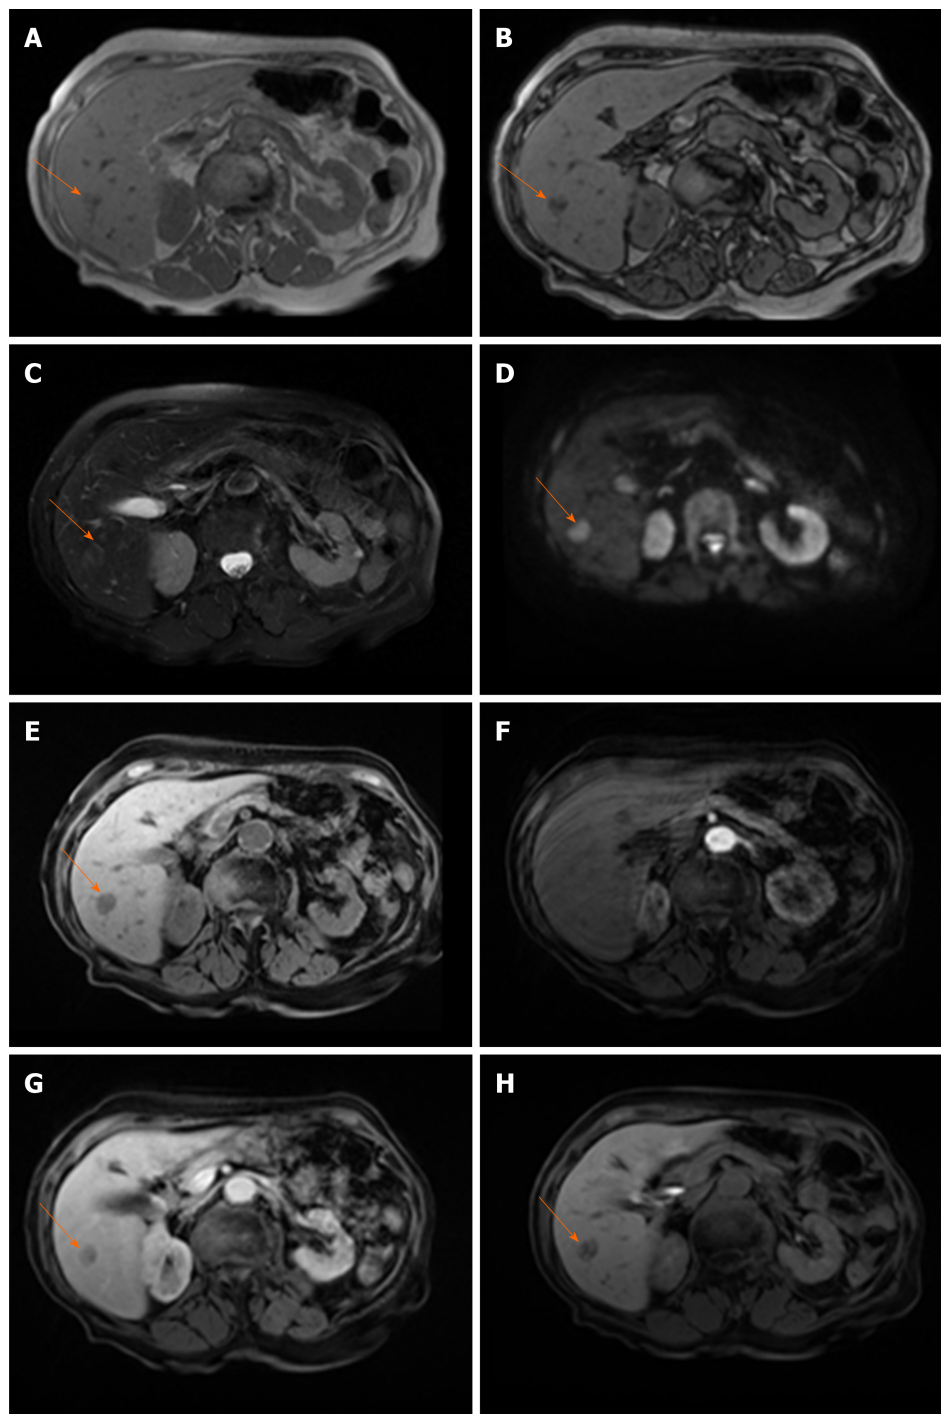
Hypovascular hepatocellular carcinoma in 58-year old woman with cirrhosis. A: On axial in-phase image tumor (arrow) is isointense with surrounding liver parenchyma; B: On opposed-phase image there is a partial drop of signal intensity in the lesion corresponding to the fatty component; C-E: The lesion (arrow) is slightly hyperintense on T2-weighted FS image (C), hyperintense on diffusion weighted imaging (D), and hypointense on T1-weighted FS image (E); F and G: On arterial phase (F) the lesion is isointense with washout in portal venous phase (G); H: On hepatobiliary phase after administration of gadoxetic acid the tumor (arrow) is hypointense.
